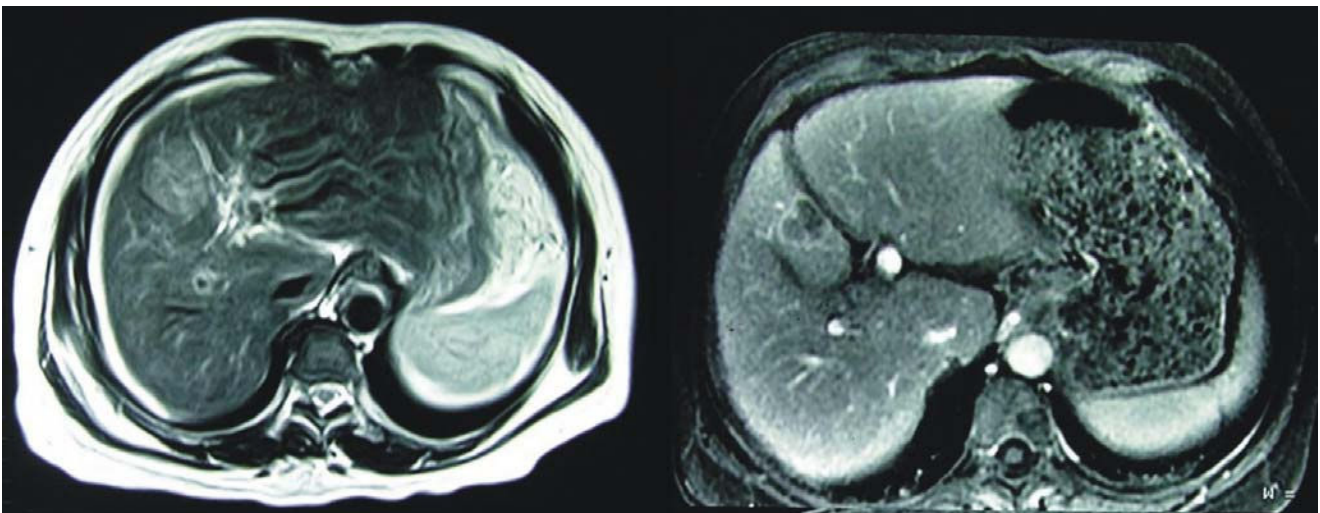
Magnetic Resonance Image showed diminishes in size tumor to 2.5 cm.
